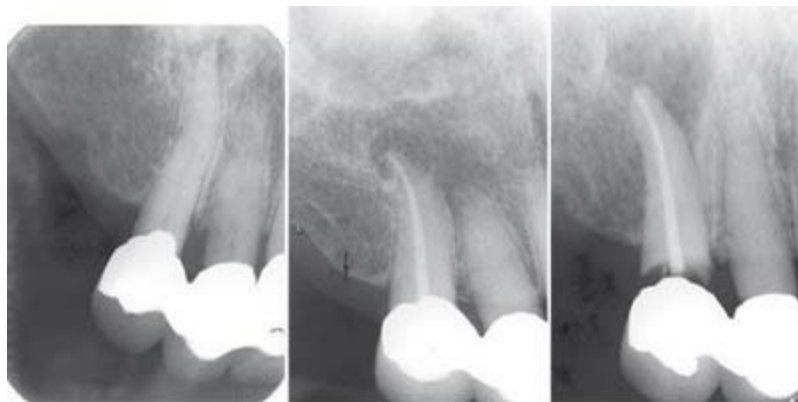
Four years after endodontic therapy, the patient complained of pain and swelling associated with tooth #6. The initial impression was that apical surgery was indicated. However, further radiographs revealed the true cause of the endodontic failure. The initial endodontic access through the crown or caries damaged the coronal seal and recurrent decay followed.
